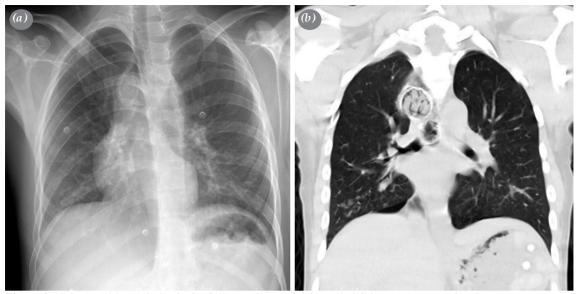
(a) A round-shaped lesion in the right superior mediastinum is visible on posteroanterior chest roentgenogram. (b) Two spherical foreign bodies, one above the other, in the esophagus are detected in the coronal plane of thoracic computed tomography.
